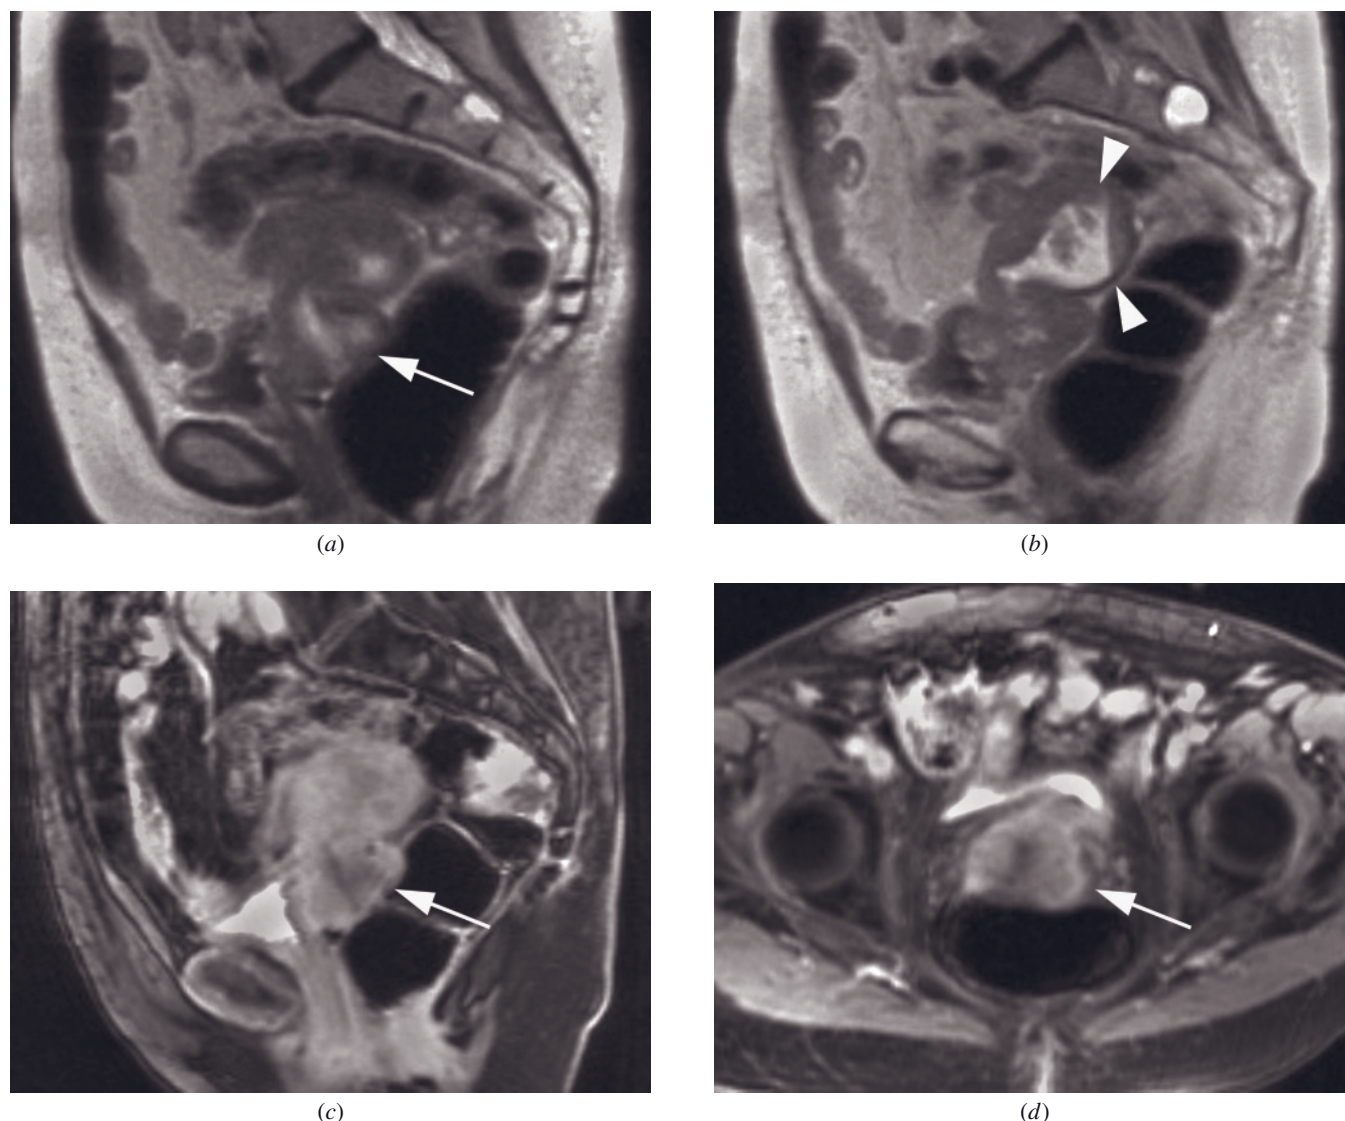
Cervical metastasis. Sagittal T2-weighted ETSE (*a, b*) and sagittal (*c*) and transverse (*d*) gadolinium-enhanced fat-suppressed T1-weighted gradient-echo images in a patient with colon cancer show an irregular cervical mass (arrow, *a, c, d*) causing uterine obstruction with hematometra (arrowheads, *b*).
